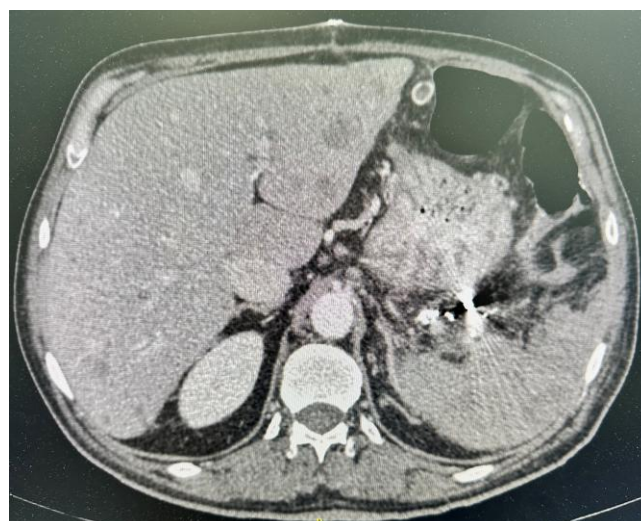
Post-embolization CT scan, were a large hematoma in the splenectomy bed was demonstrated.
